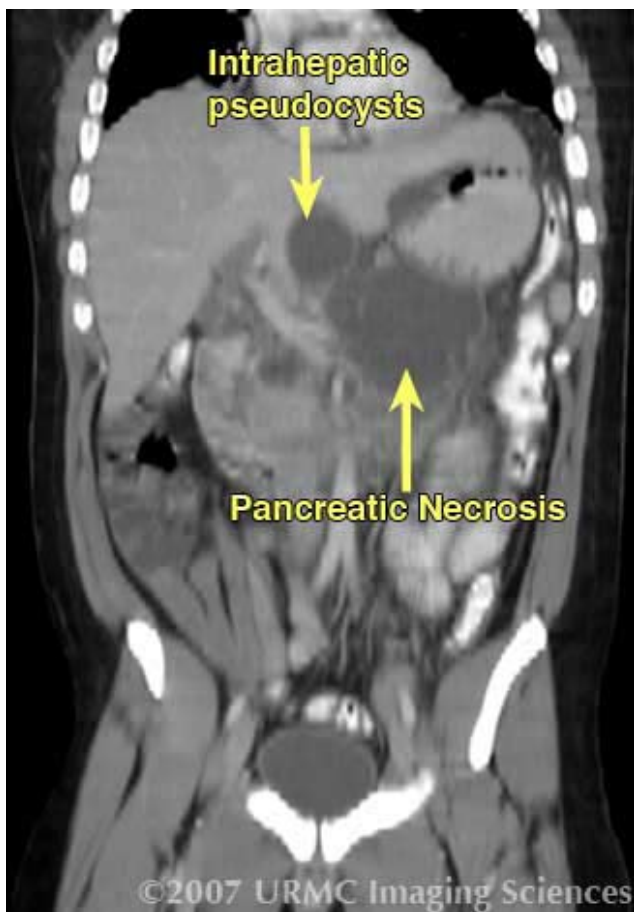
Coronal CT image demonstrates pancreatic necrosis with adjacent intrahepatic pseudocysts superiorly.
